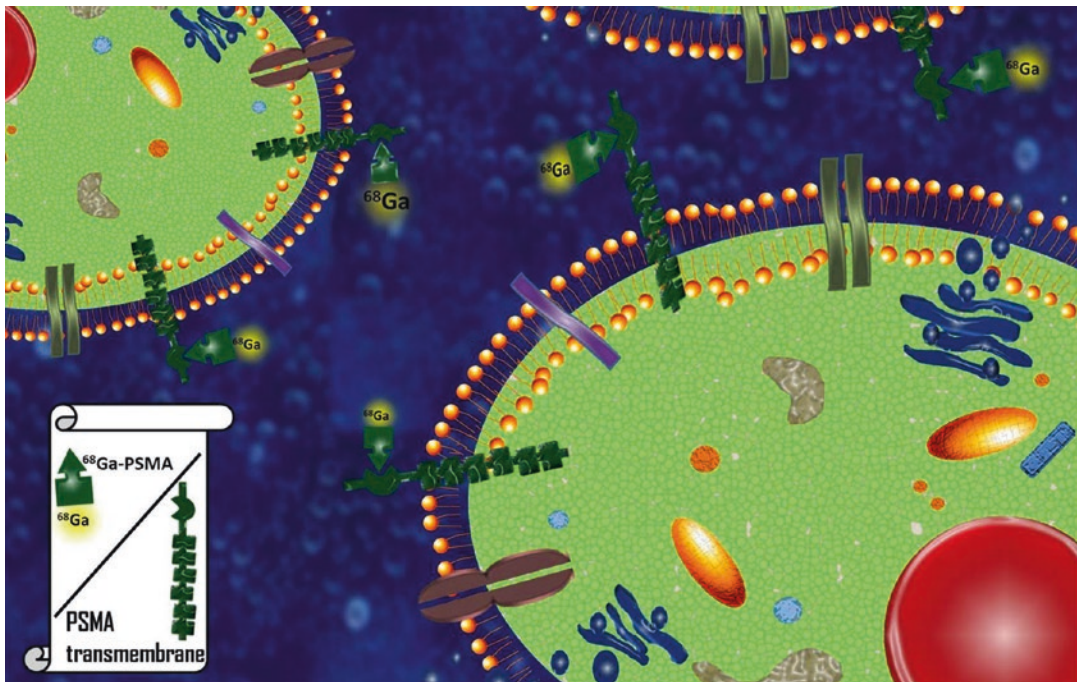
^{68}Ga labelled PSMA binds to the extracellular domain by small specific inhibitors that are internalized after ligand binding. A high level of accumulation can be reached even in small metastases of prostate cancer
